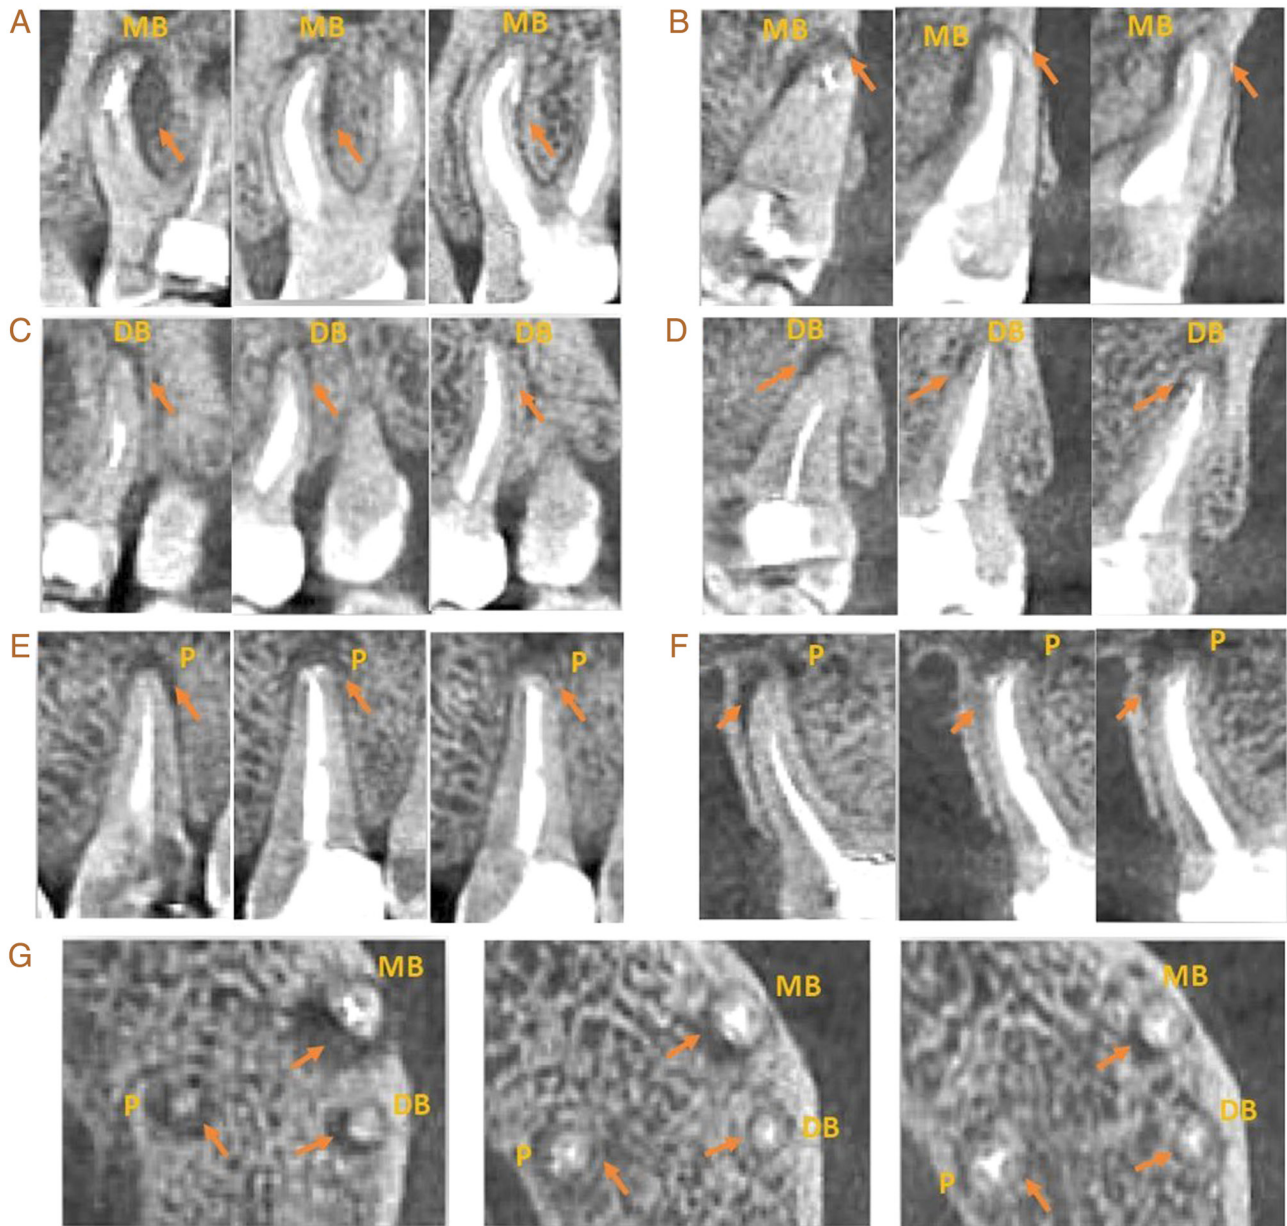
Follow-up observation of tooth no. 26 via X-ray. (A) Sagittal X-ray of the MB root. The first was taken before the operation, the second was taken 9 months after the operation and the third was taken 27 months after the operation. (B) Coronal X-ray of the MB root. The first was taken before the operation, the second was taken 9 months after the operation and the third was taken 27 months after the operation. (C) Sagittal X-ray of the DB root. The first was taken before the operation, the second was taken 9 months after the operation and the third was taken 27 months after the operation. (D) Coronal X-ray of the DB root. The first was taken before the operation, the second was taken 9 months after the operation and the third was taken 27 months after the operation. (E) Sagittal X-ray of the P root. The first was taken before the operation, the second was taken 9 months after the operation and the third was taken 27 months after the operation. (F) Coronal X-ray of the P root. The first was taken before the operation, the second was taken 9 months after the operation and the third was taken 27 months after the operation. (G) Cross-sectional X-ray of the three types of roots. The first was taken before the operation, the second was taken 9 months after the operation and the third was taken 27 months after the operation. MB, mesiobuccal; FI, fractured instrument; DB, distal buccal; P, palatal.
